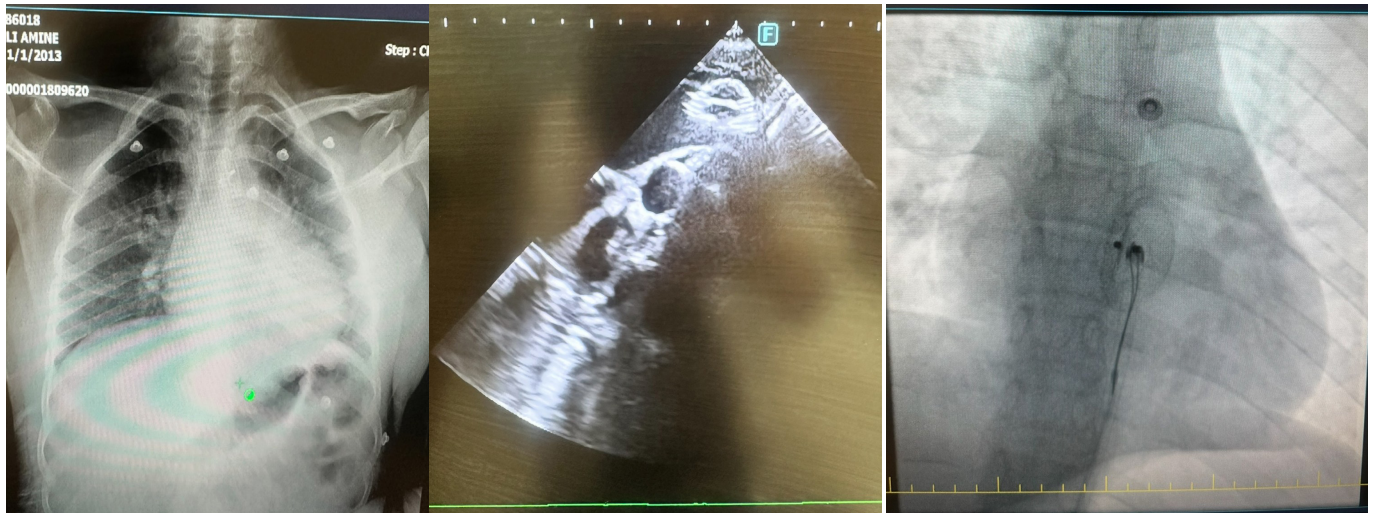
Postprocedural chest X-ray Figure 2. Control echocardiography Figure 3. The ASD device was snared in the aortic arch
